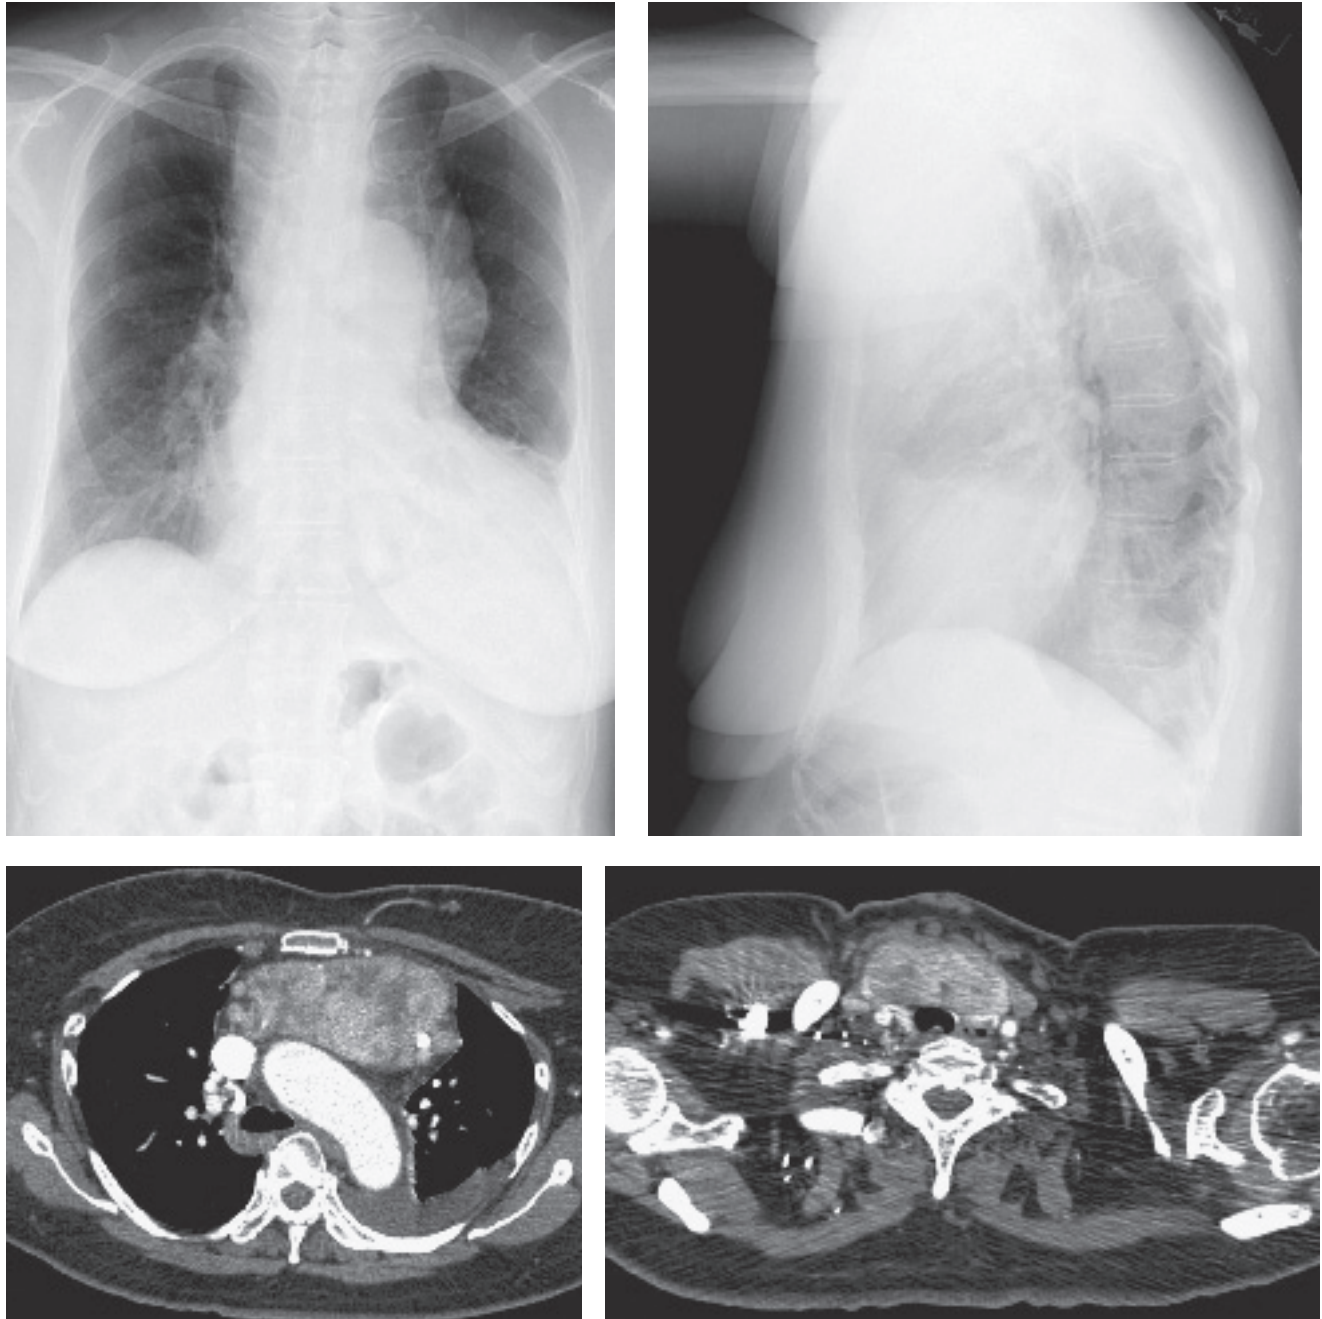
(A) Posteroanterior radiograph shows a lobulated mediastinal mass that does not silhouette the aortic arch. (B) Lateral radiograph shows that the retrosternal clear space is obscured. Enhanced axial computed tomography images reveal (C) a heterogeneously enhancing anterior mediastinal mass with coarse foci of calcification that is contiguous with (D) the thyroid gland.
